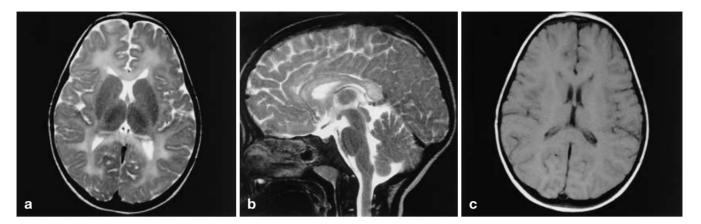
T2-weighted spin-echo images show diffuse confluent increase in signal intensity in white matter and homogeneous involvement of the corpus callosum. c T1-weighted spin-echo image shows decreased grey/white matter contrast
